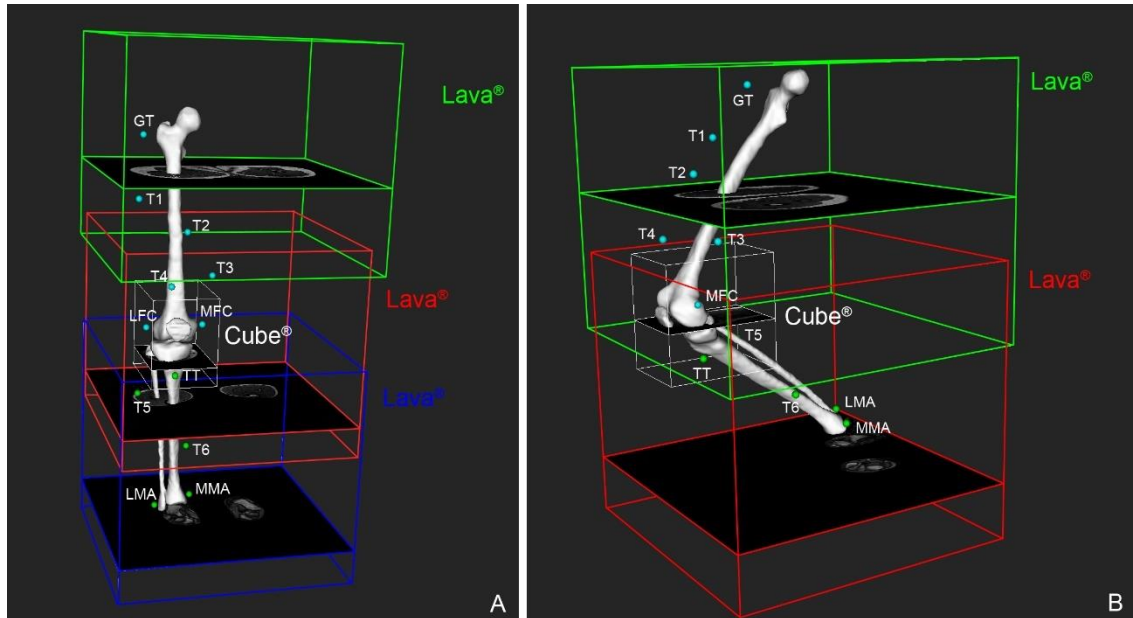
MRI volumes acquired A) in neutral knee flexion (frontal view) and B) at 90° knee flexion (lateral view). Markers are also shown. GT = greater trochanter, LFC = lateral femoral epicondyle, MFC = medial femoral epicondyle, TT = tibial tuberosity, MMA = medial malleoli, LMA = lateral malleoli, T1-T6 = technical markers.
